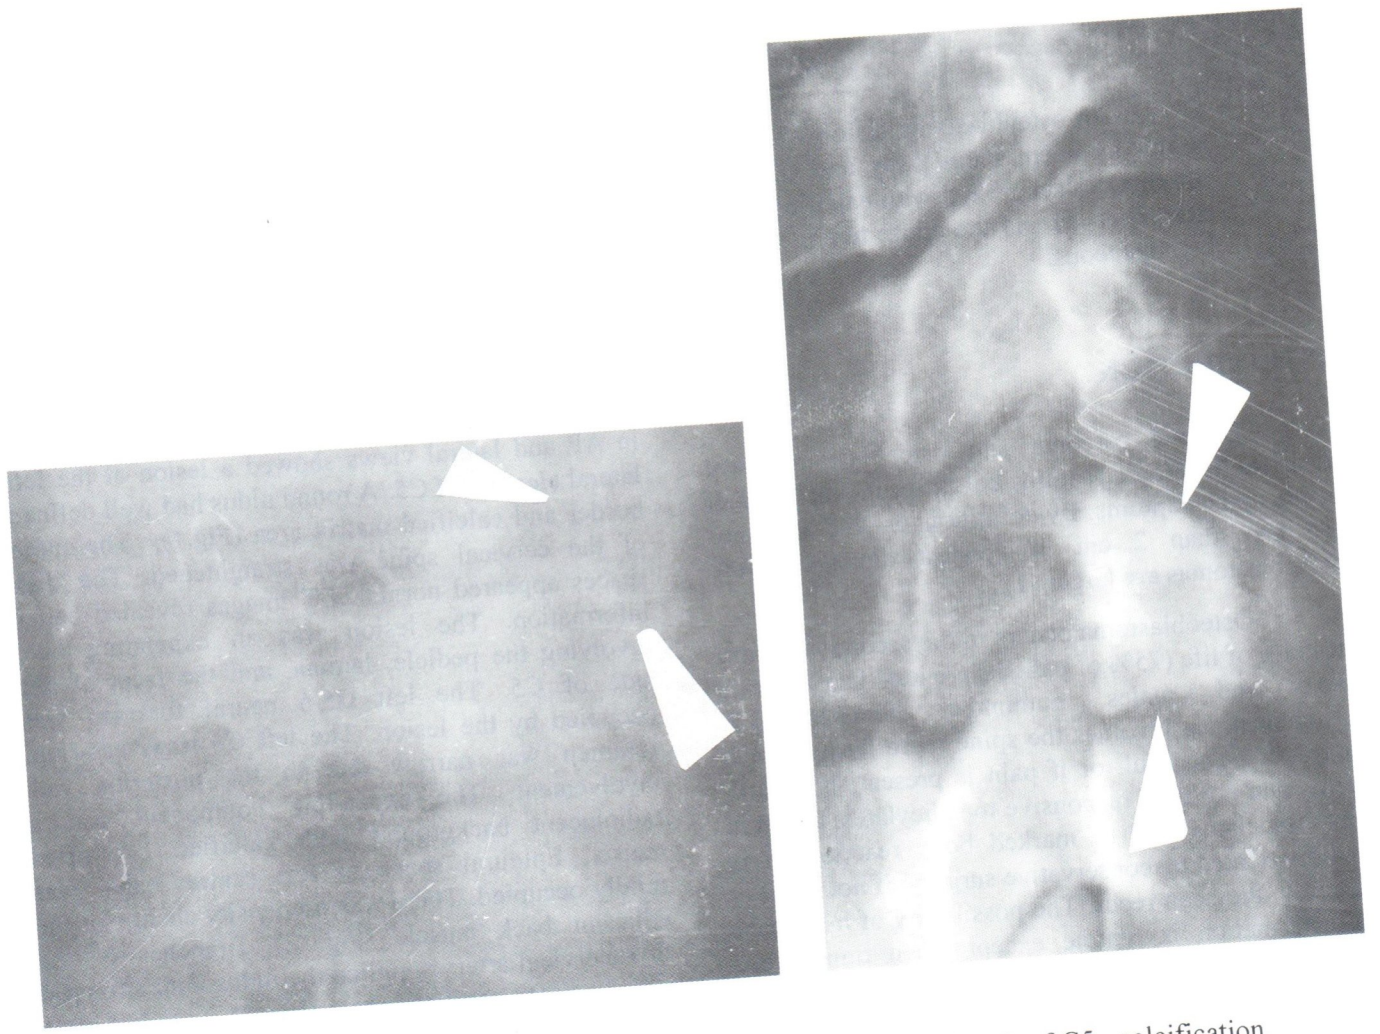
Plain films of the cervical spine of the lesion at left lateral arch of C5, calcification in the nidus was obvious.
